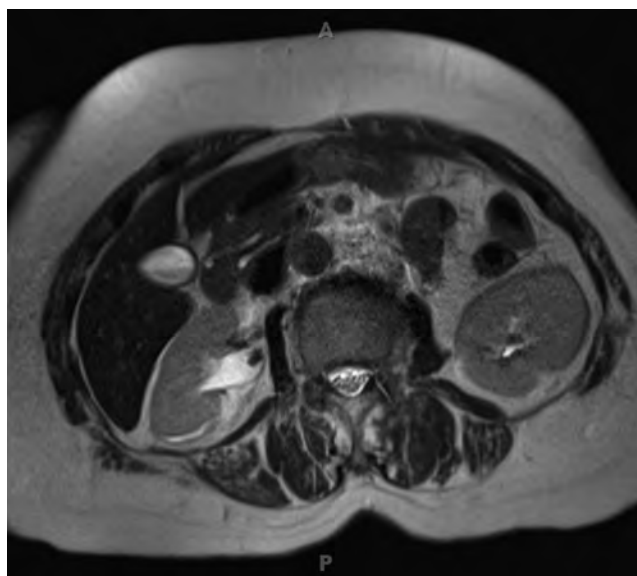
Magnetic resonance urogram from a pregnant woman with right renal colic, demonstrating a right ureteropelvic junction stone as a filling defect in the bright, T2-weighted urinary collecting system.
